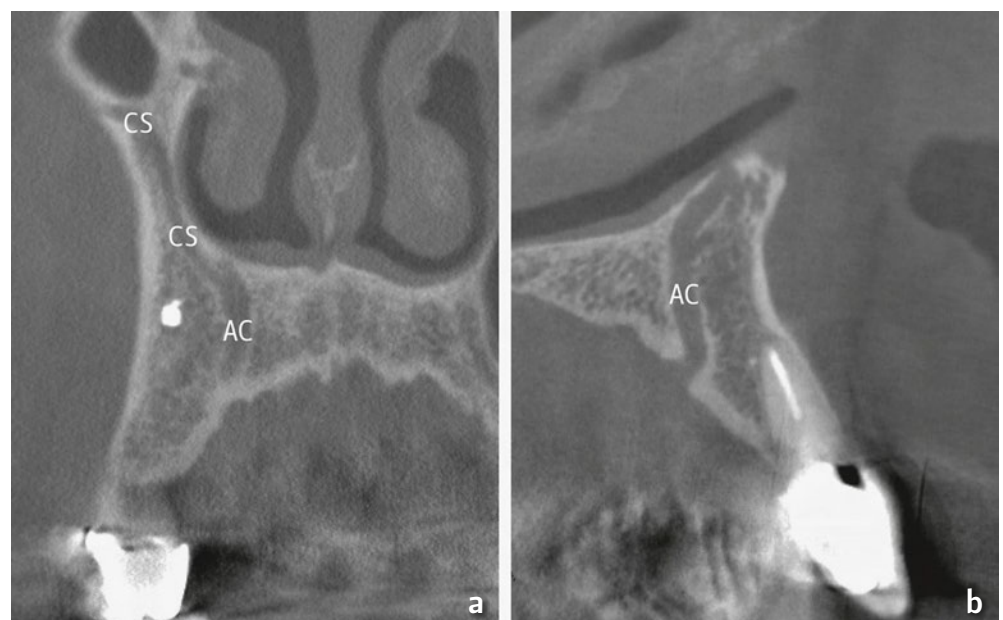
Coronal (a) and sagittal (b) reformatted CBCT images of a 72-year old male showing AC (originating from CS) reaching the palate posterior to the right lateral maxillary incisor.
